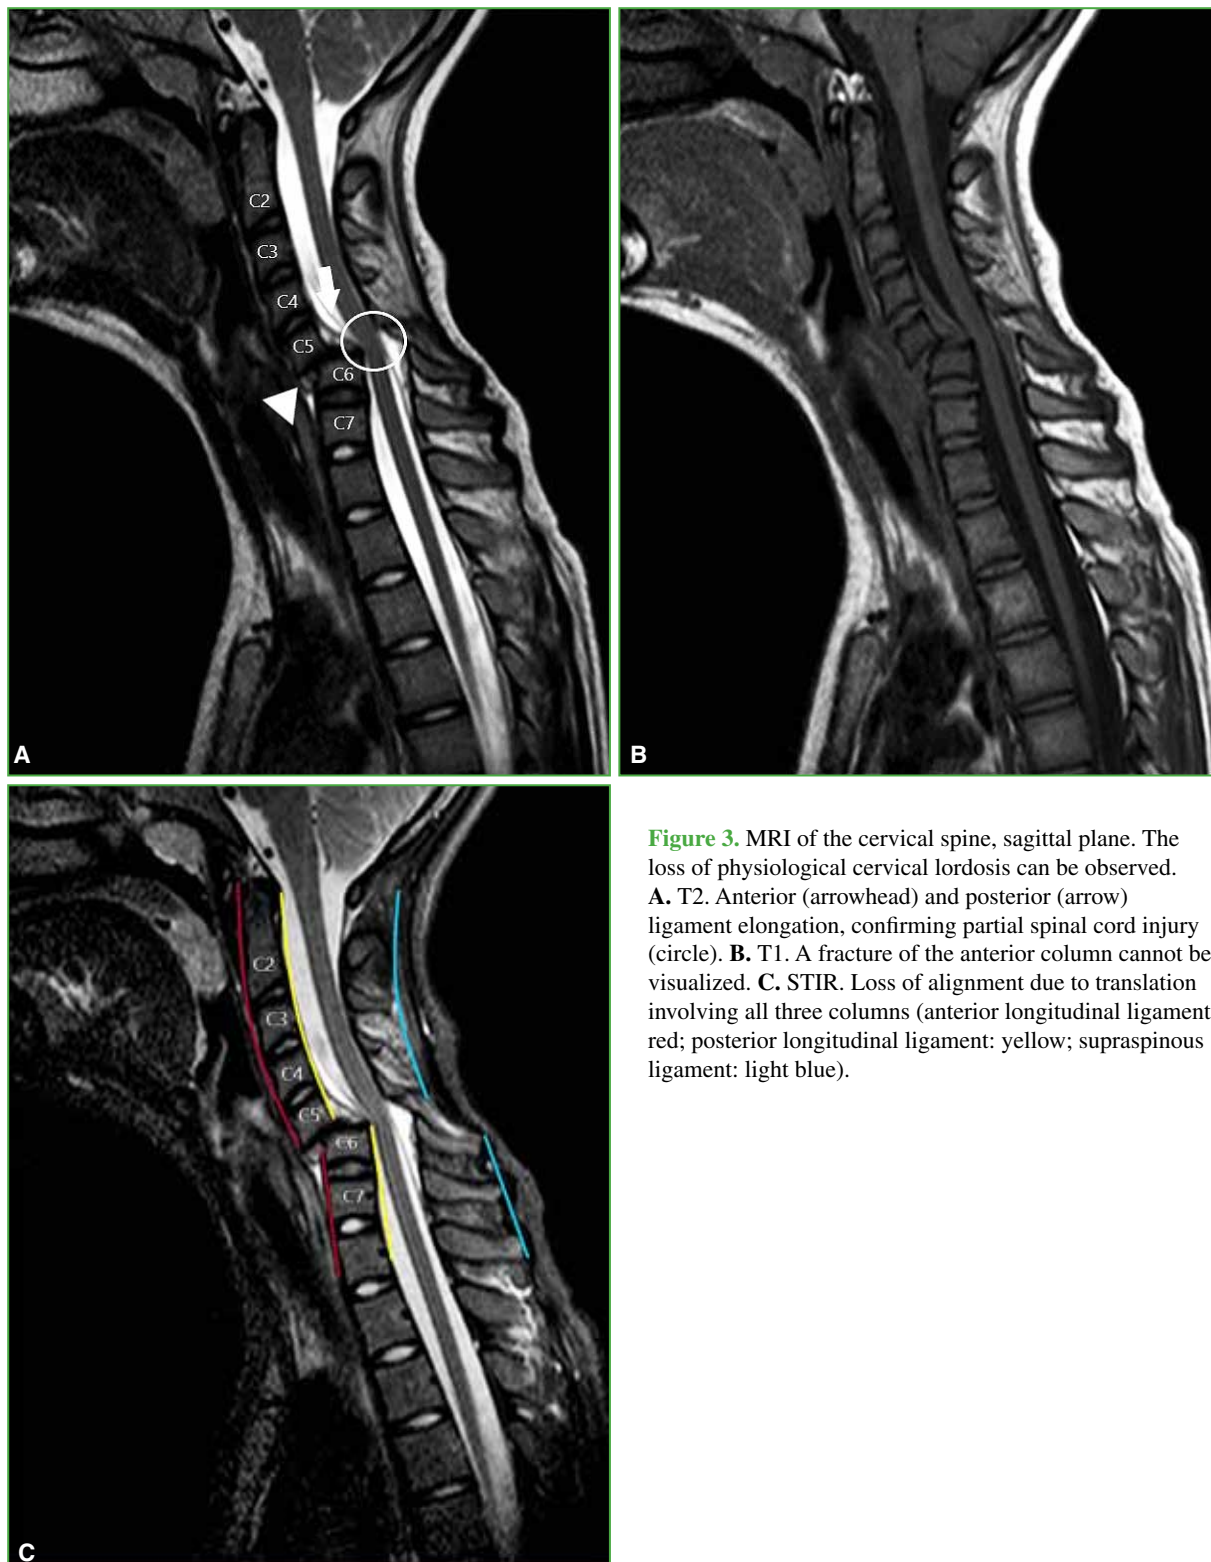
MRI of the cervical spine, sagittal plane. The loss of physiological cervical lordosis can be observed. A. T2. Anterior (arrowhead) and posterior (arrow) ligament elongation, confirming partial spinal cord injury (circle). B. T1. A fracture of the anterior column cannot be visualized. C. STIR. Loss of alignment due to translation involving all three columns (anterior longitudinal ligament: red; posterior longitudinal ligament: yellow; supraspinous ligament: light blue).
